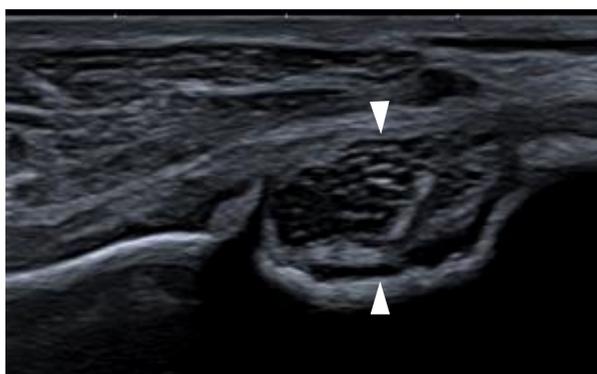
Transverse ultrasonographic images of the right maxillary bone at the level of the infraorbital foramen showing irregular spiculated periosteal bone reaction. Infraorbital nerve is indicated between arrowheads.
